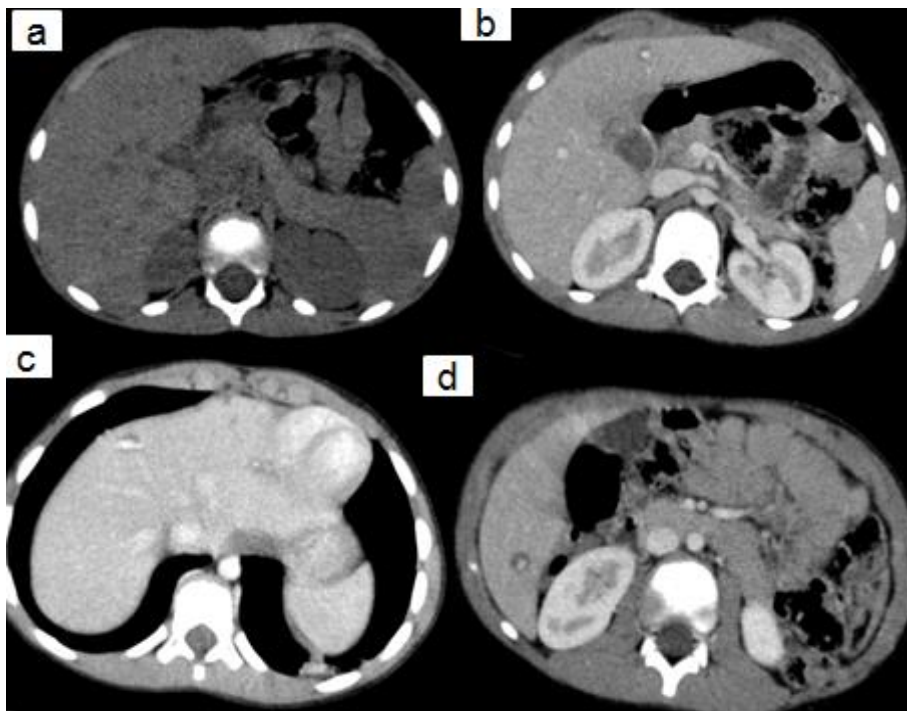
CT scan without (a) and with contrast (b,c and d) well-margined hypodense lesions with a peripheral nodular enhancement that matches the aorta at the arterial phase (c) and progressive centripetal filling on venous phase (b and d)
